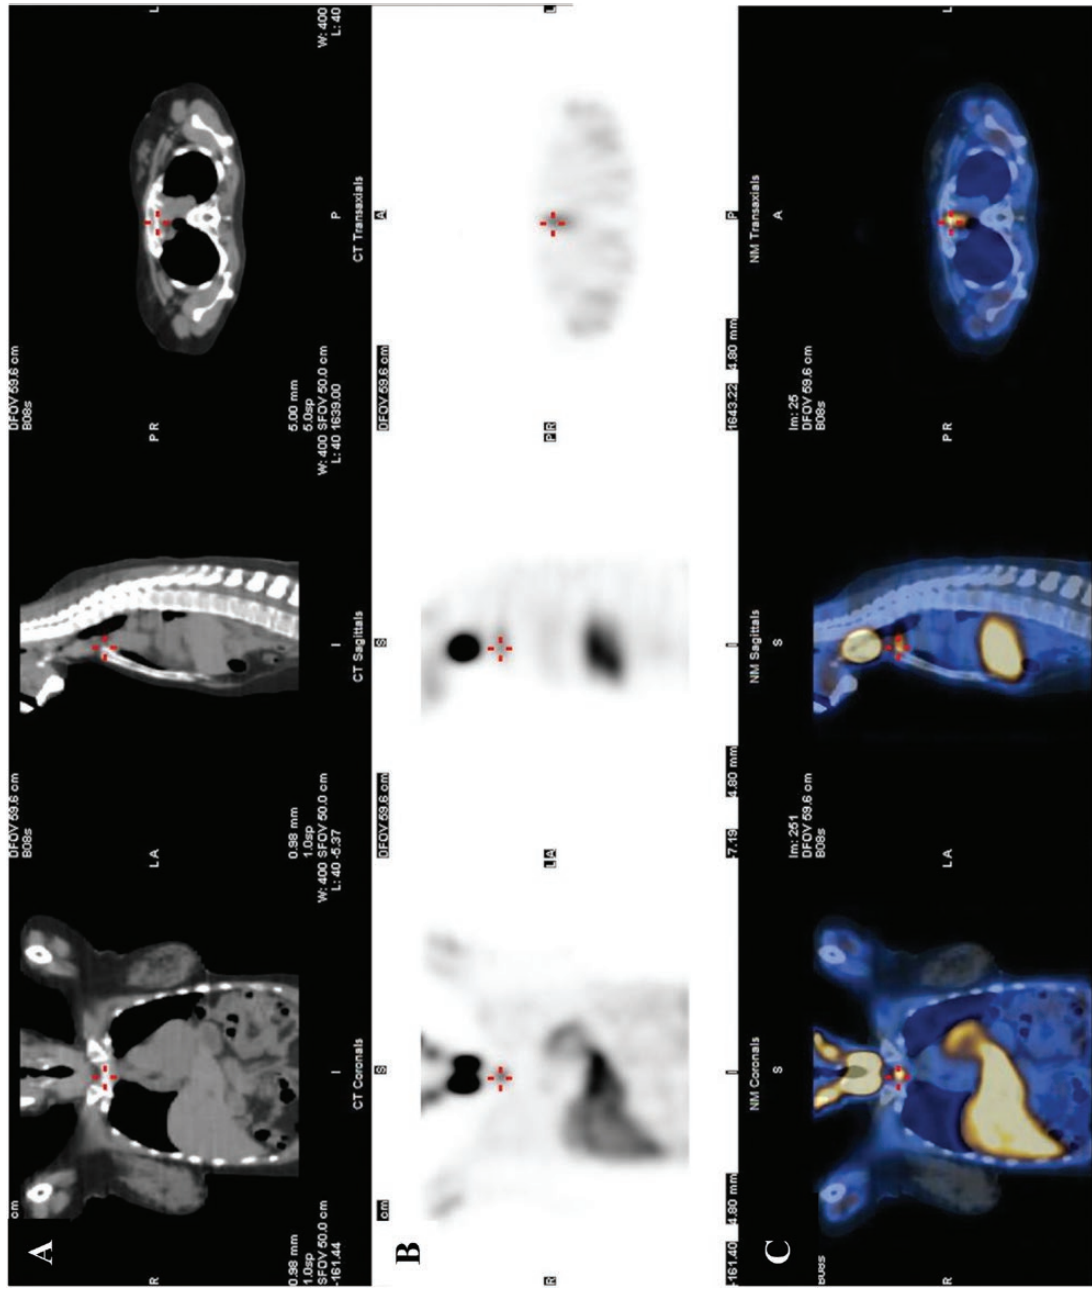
Case 1 ¹²³I-mIBG scan. A: CT for localization and attenuation correction. B: SPECT images. C: Fused SPECT/CT images localizing the lesion to the upper mediastinum.
